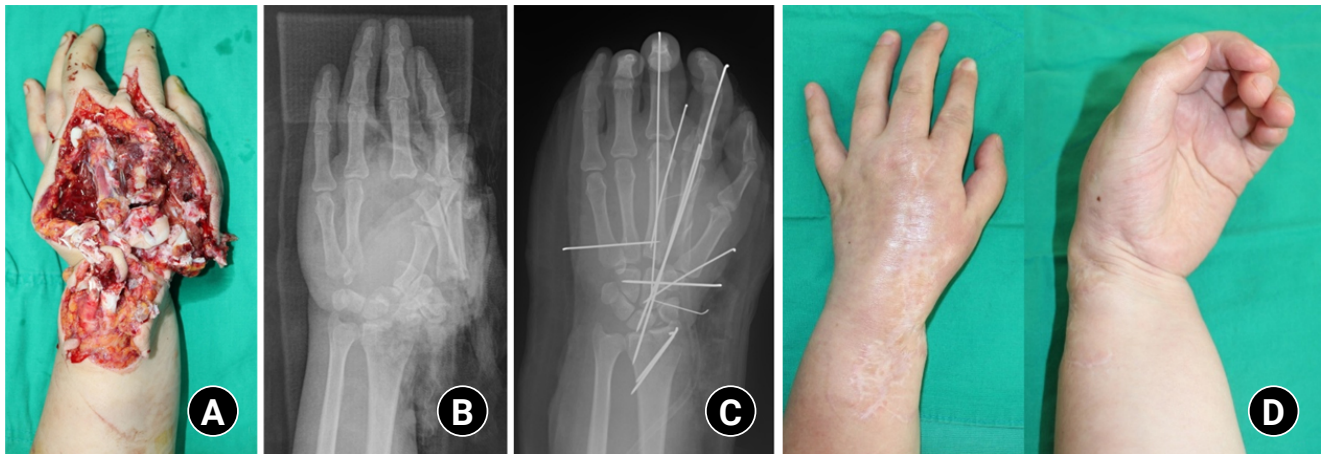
(A) A case with multiple open hand fracture-dislocations and severe soft tissue injury. (B) Preoperative plain radiograph shows multiple hand and wrist fractures and dislocations. (C) A postoperative plain radiograph shows that temporary K-wire fixation was performed to maintain bony alignment and manage soft tissue injury. (D) The last follow-up photograph shows severe finger stiffness and permanent disability.
